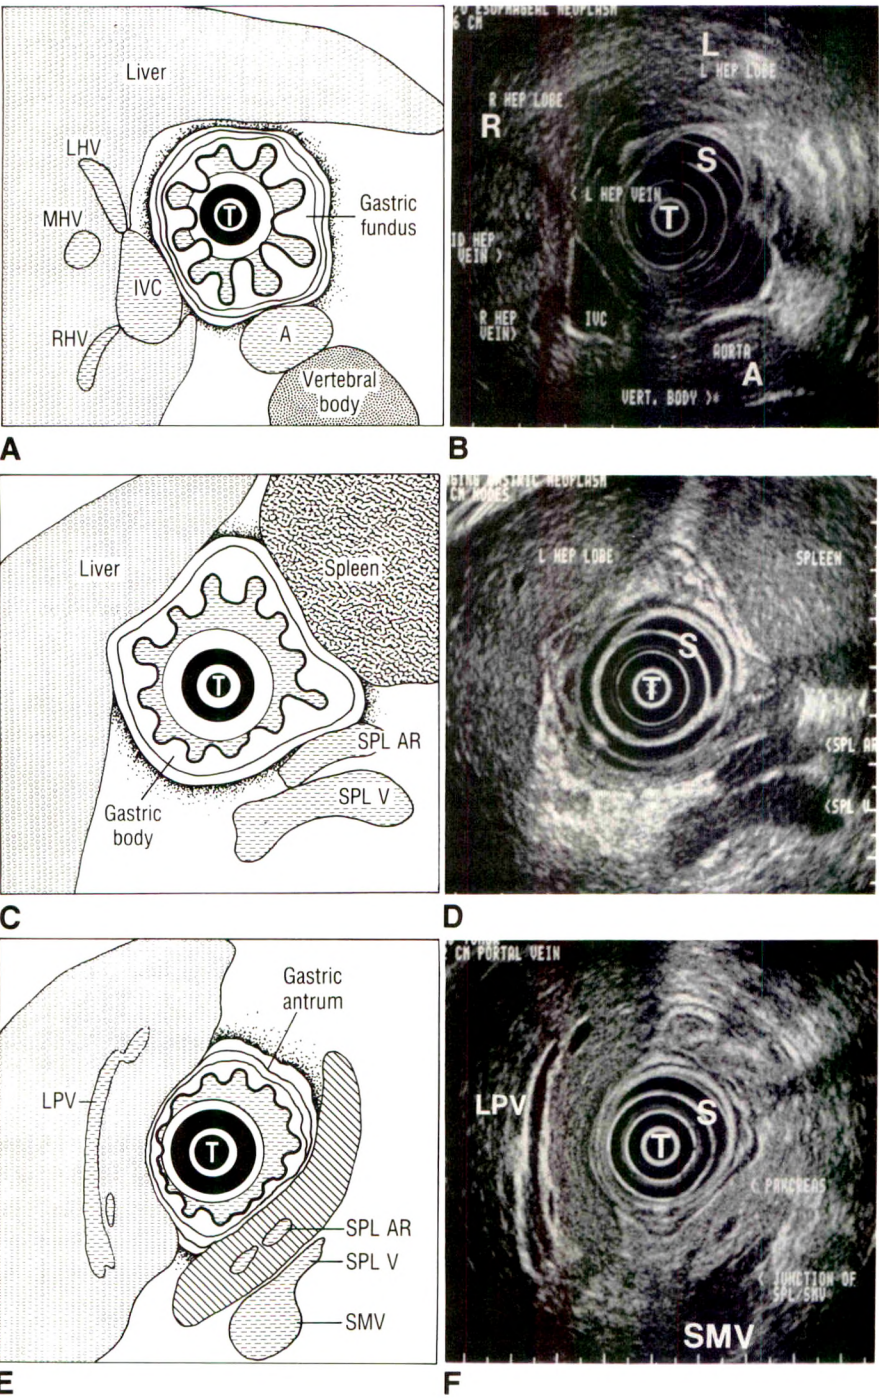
Endoscopic sonography of normal stomach with 7.5-MHz transducer (T).
